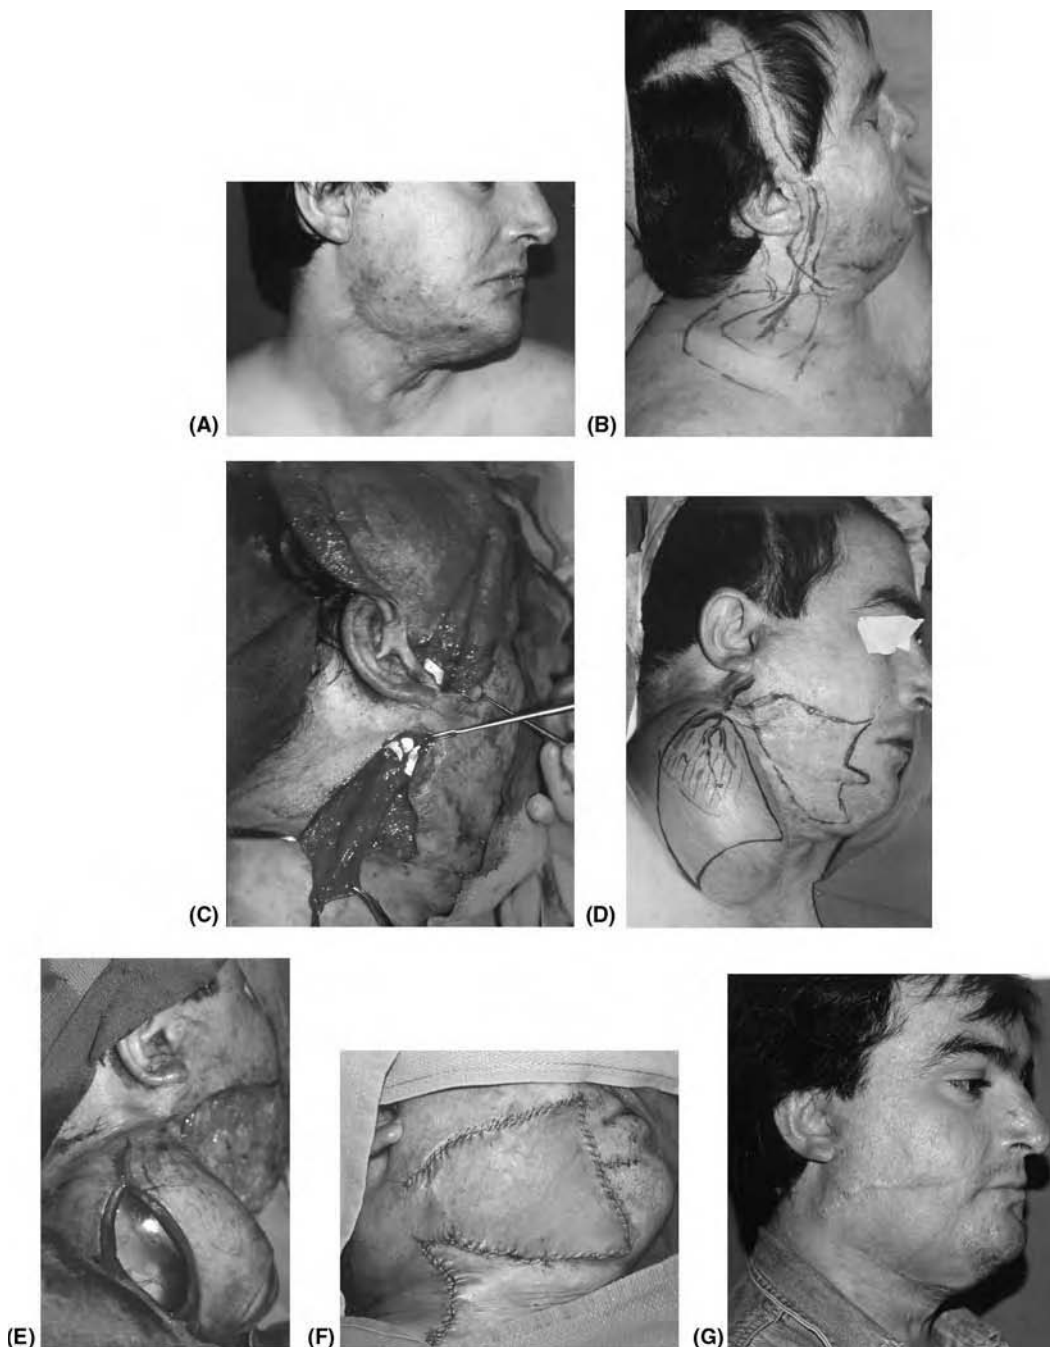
Flap prefabrication. (A) A 25-year-old man with a painful, hypertrophic burn scar on the right cheek and jaw. (B) Design of flap prefabrication using superficial temporal vessels and TPF, which will be rotated into normal upper neck area. (C) Intraoperative view of pedicle and TPF, surrounded by Gore-Tex® cuff around its base, being placed into the lower neck; it will be placed directly underneath the skin and over a tissue expander, which is minimally inflated initially. (D) Eight weeks later, at the time of scar excision and flap transfer, the expanded, prefabricated flap has an excellent Doppler signal. (E) Intraoperative view of the raised prefabricated flap, the underlying tissue expander, and the recipient bed, where the burn scar has just been excised. (F) After the prefabricated flap is inset and donor site is closed. (G) Three months after the prefabricated flap transfer. *Abbreviation:* TPF, temporoparietal fascia.
